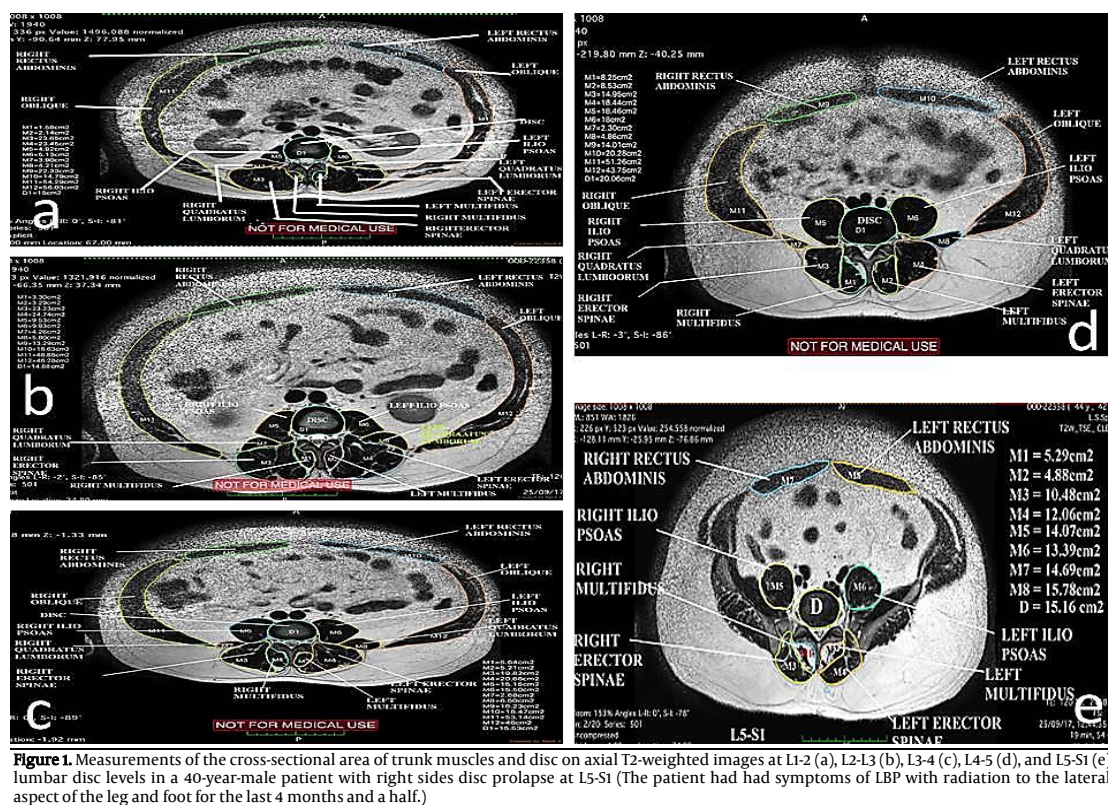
Measurements of the cross-sectional area of trunk muscles and disc on axial T2-weighted images at L1-2 (a), L2-L3 (b), L3-4 (c), L4-5 (d), and L5-S1 (e) lumbar disc levels in a 40-year-old male patient with right-side disc prolapse at L5-S1 (The patient had had symptoms of LBP with radiation to the lateral aspect of the leg and foot for the last 4 months and a half.)
